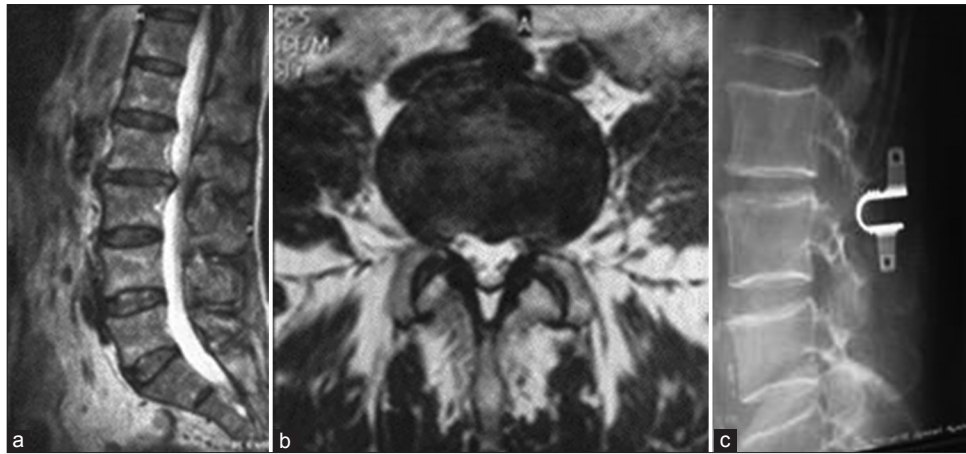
(a) Sagittal T2 magnetic resonance imaging image showing L2-L3 Bi-foraminal Stenosis. (b) Axial T2 MRI image showing L2-L3 Bi-foraminal Stenosis. (c) Plain lumbar X-ray after insertion of interspinous spacer
